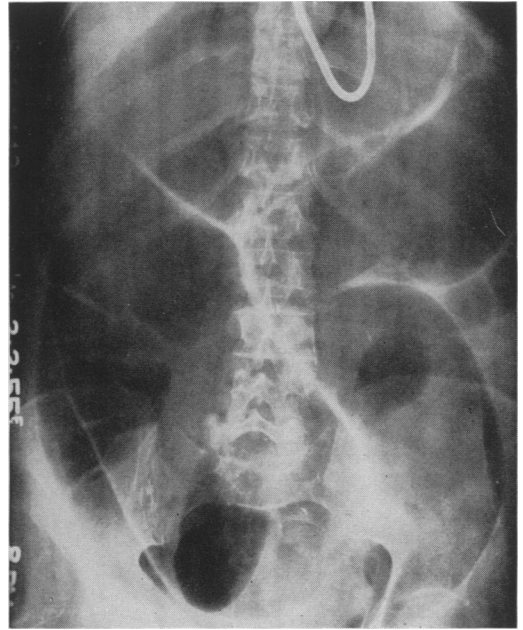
A supine abdominal roentgenogram showing marked sigmoid loop distention with the bent inner-tube effect.
